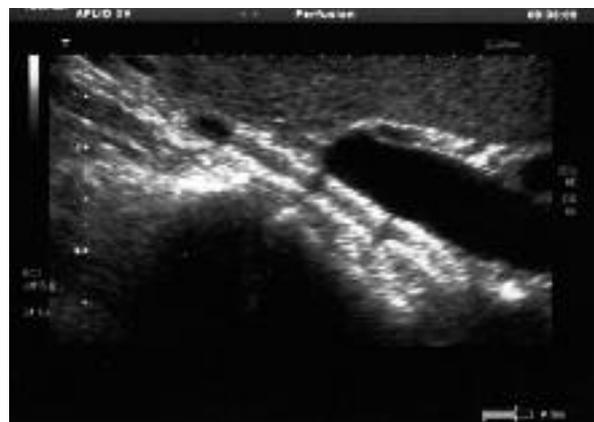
Color Doppler ultrasound scan showing the presence of three stents on the right renal artery.
